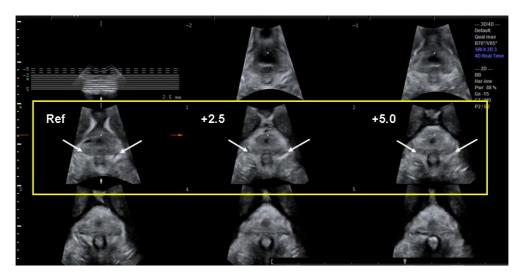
Major bilateral defect of the levator ani (LA) muscle 6 weeks after delivery. Tomographic ultrasound in the axial plane of the levator hiatus, obtained with a 2.5-mm slice interval, from 5 mm caudally to 12.5 mm cranially. Major LA defect visualised as abnormal insertion (arrows) present in all three central slices (slices shown within yellow border). From BJOG 2013;120(11); Hilde G et al 2013; DOI: 10.1111/1471-0528.12321.
